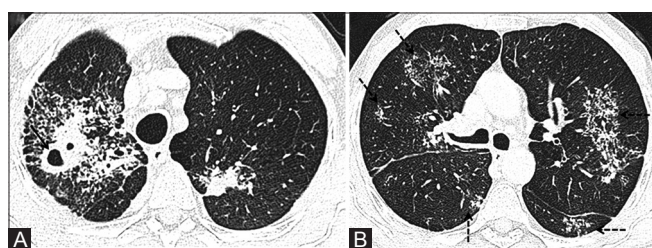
(A and B): Tuberculosis with perilymphatic nodules and cluster sign. 36-year old man with fever, cough and progressive weight loss for 5 months. GeneXpert MTB from bronchoalveolar lavage (BAL) fluid was positive. (A) Axial high resolution computed tomography (HRCT) image shows thick-walled cavity with adjacent consolidation in right upper lobe (black arrow). Multiple adjacent coalescent ill-defined air-space nodules are noted. Smaller area of consolidation also noted in left upper lobe. (B) Axial HRCT image (at lower level) shows multiple clusters of discrete micronodules bilaterally along with nodular thickening of right major fissure suggestive of lymphatic spread (dashed arrows)
